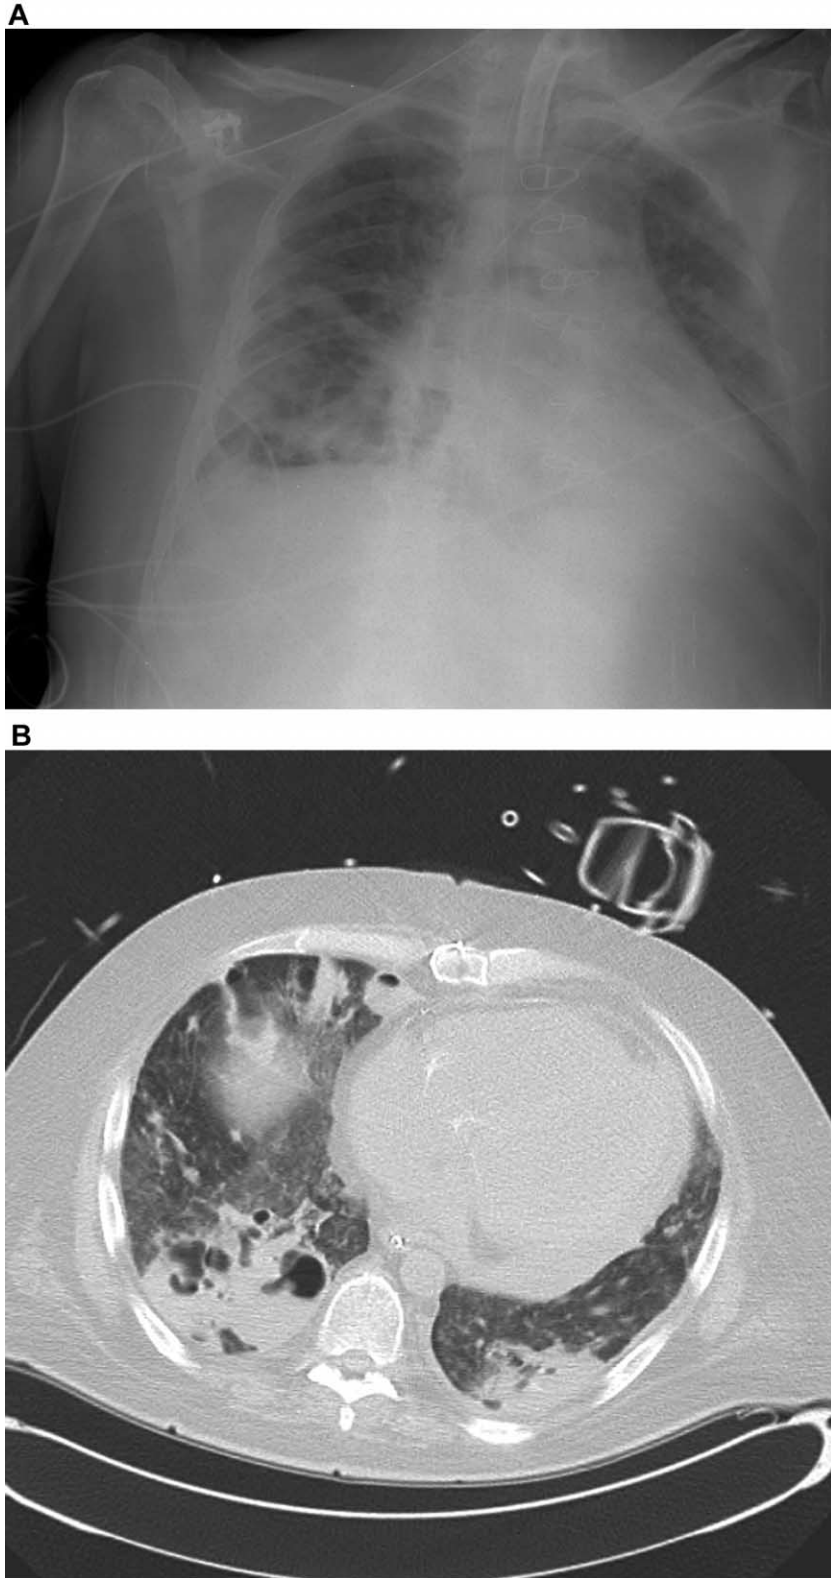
Chest radiograph (A) and CT (B) obtained 2 months after kidney transplantation in a patient with end-stage diabetes. Bilateral lower lobe cavities with adjacent pleural effusion on the right side are seen. Transbronchial biopsy revealed *Aspergillus fumigatus*. The serum and bronchoalveolar lavage galactomannan levels were 0.1 and 5.7 ng/mL, respectively. Despite the administration of antifungal treatment, the patient died of proven *Aspergillus* endocarditis of the tricuspid valve.
